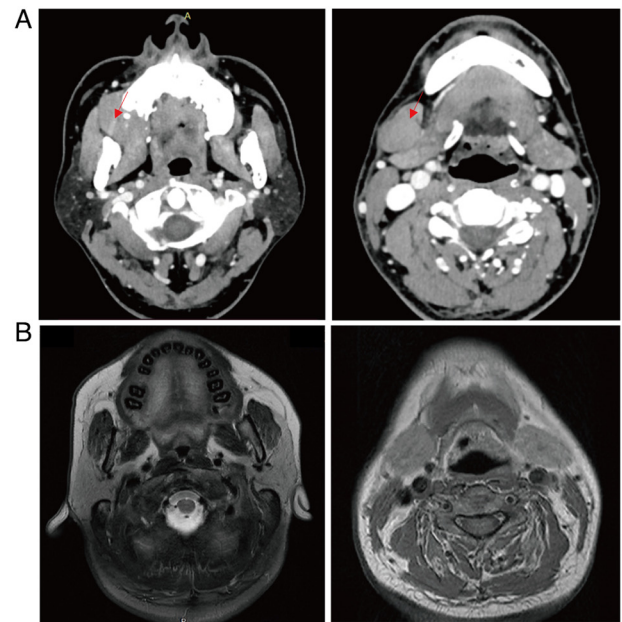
Preoperative gingival excision biopsy CT and postoperative MRI images (August 2017). (A) Preoperative CT shows a mass in the right upper gingiva and right lower mandible (red arrow). (B) Postoperative MRI shows no distinct lesion. CT, computed tomography; MRI, magnetic resonance imaging.
